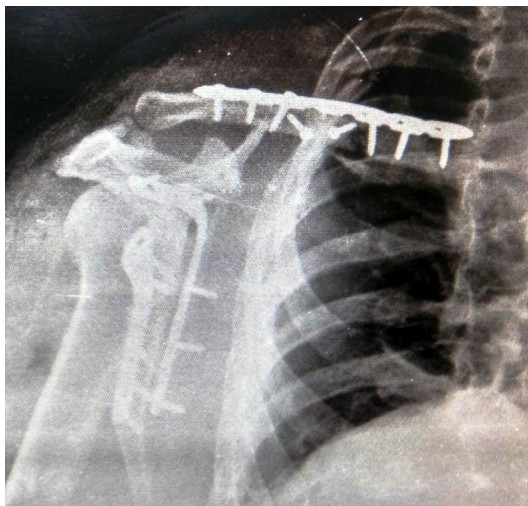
Case 1: Post-op X-ray Lat view (2 plates in Scapula, clavicle fixed with plate)
